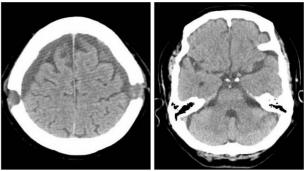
Postoperative computed tomography images taken on postoperative day 14 show resolution of the cerebellar hemorrhage.
